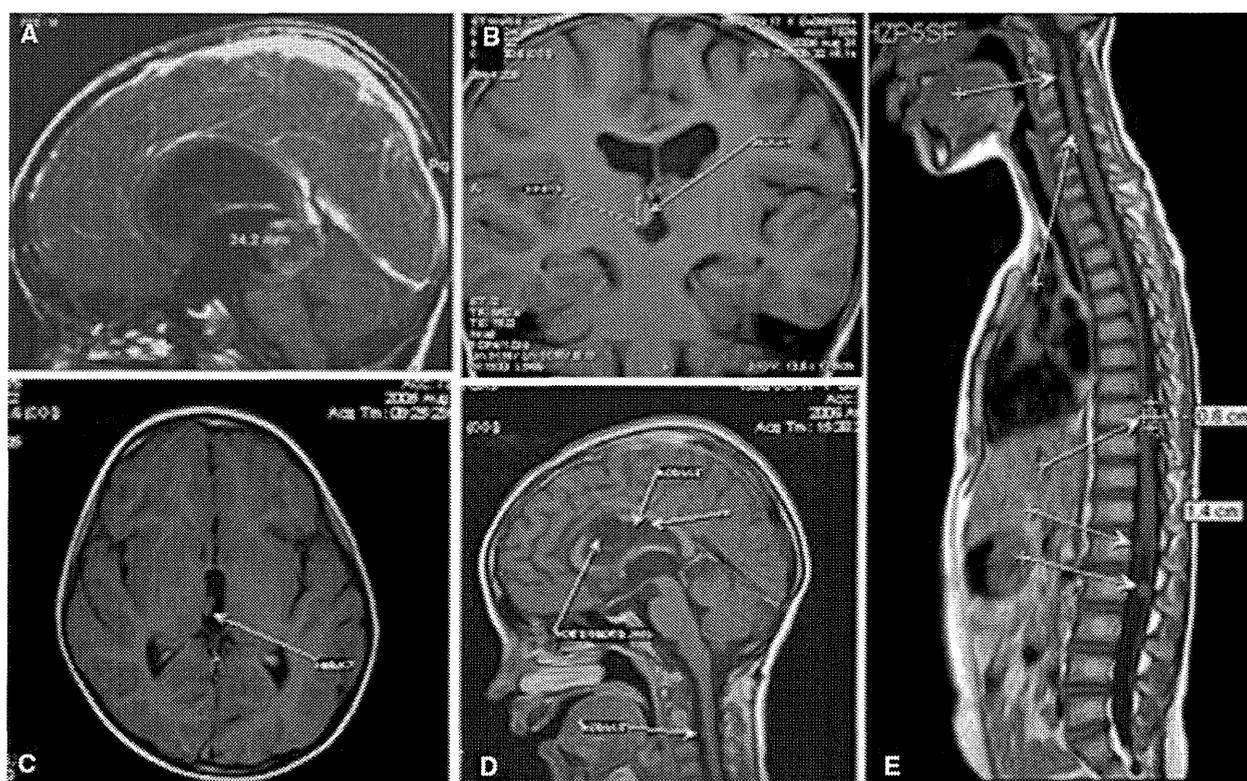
Magnetic resonance imaging features in case 22. All images are T1-weighted gadolinium-enhanced magnetic resonance imaging scans. a Sagittal image of the lesion at presentation, showing a 28 mm (largest diameter) mass in the pineal region prior to first surgery (total tumor removal). Coronal (b) and axial (c) images showing a first
